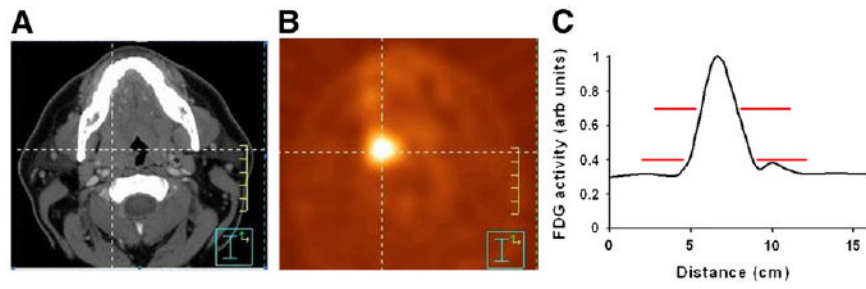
CT (A) and ^{18}F -FDG PET (B) transverse slices for patient with base-of-tongue cancer, and profile plot of ^{18}F -FDG signal along horizontal line (C). Example ^{18}F -FDG signal threshold levels (red lines, C) demonstrate that cutoff levels of 40% and 70% of maximum would result in very different tumor volumes.
